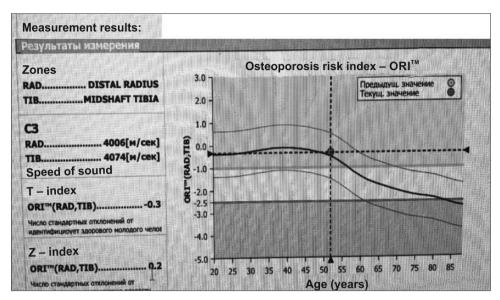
The result of ultrasound examination of patient O, 52 years old T-index: from -1.0 to +1 – norm; from -1.0 to -2.5 – osteopenia; < -2.5 – osteoporosis
